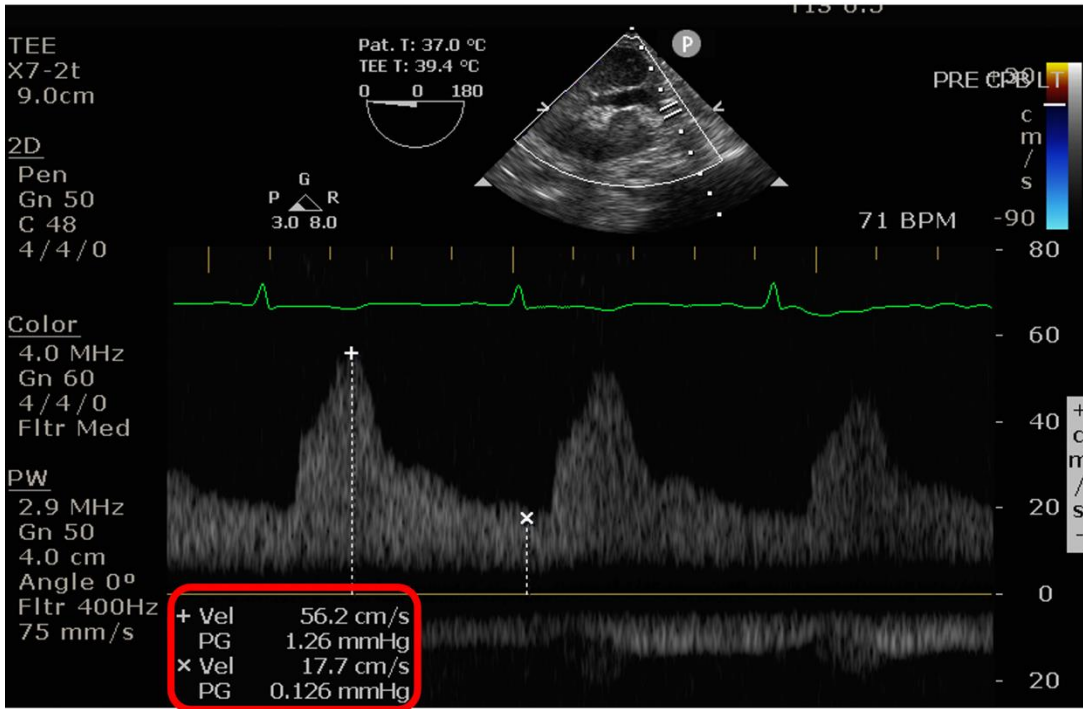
showing pulse wave doppler of renal artery demonstrating peak systolic velocity (+) and minimum diastolic velocity (x)
